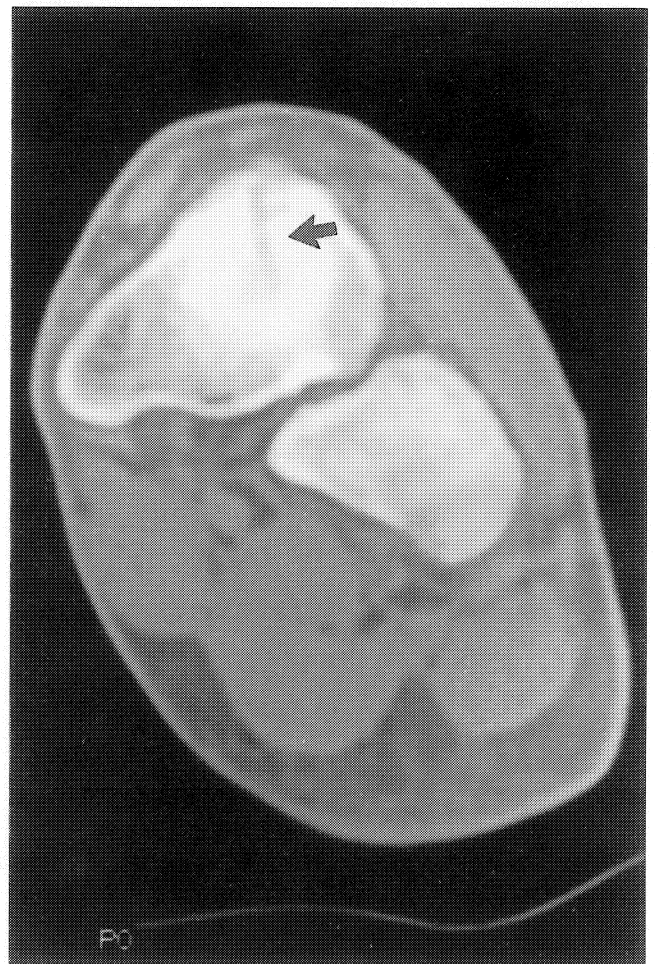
CT scan with image parallel to the talonavicular joint demonstrates incomplete stress fracture of the navicular (arrow).
